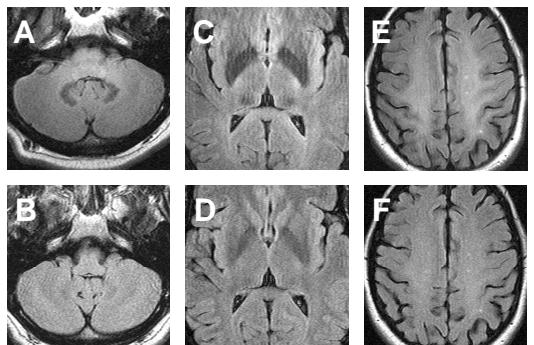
Fast FLAIR images at 3.0 T (A, C, E) show increased conspicuity of low signal intensities at dentate nucleus of cerebellum (A) and pulvinar thalami (B), and high conspicuity of high signal intensities at both centrum semiovales (E), compared with 1.5 T (B, D, F).
